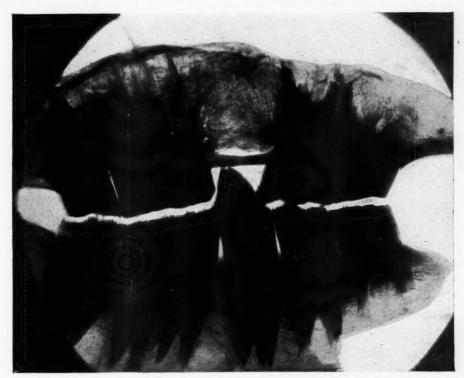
Radiograph of jaws of buffalo (Bison americanus), showing missing molar.
